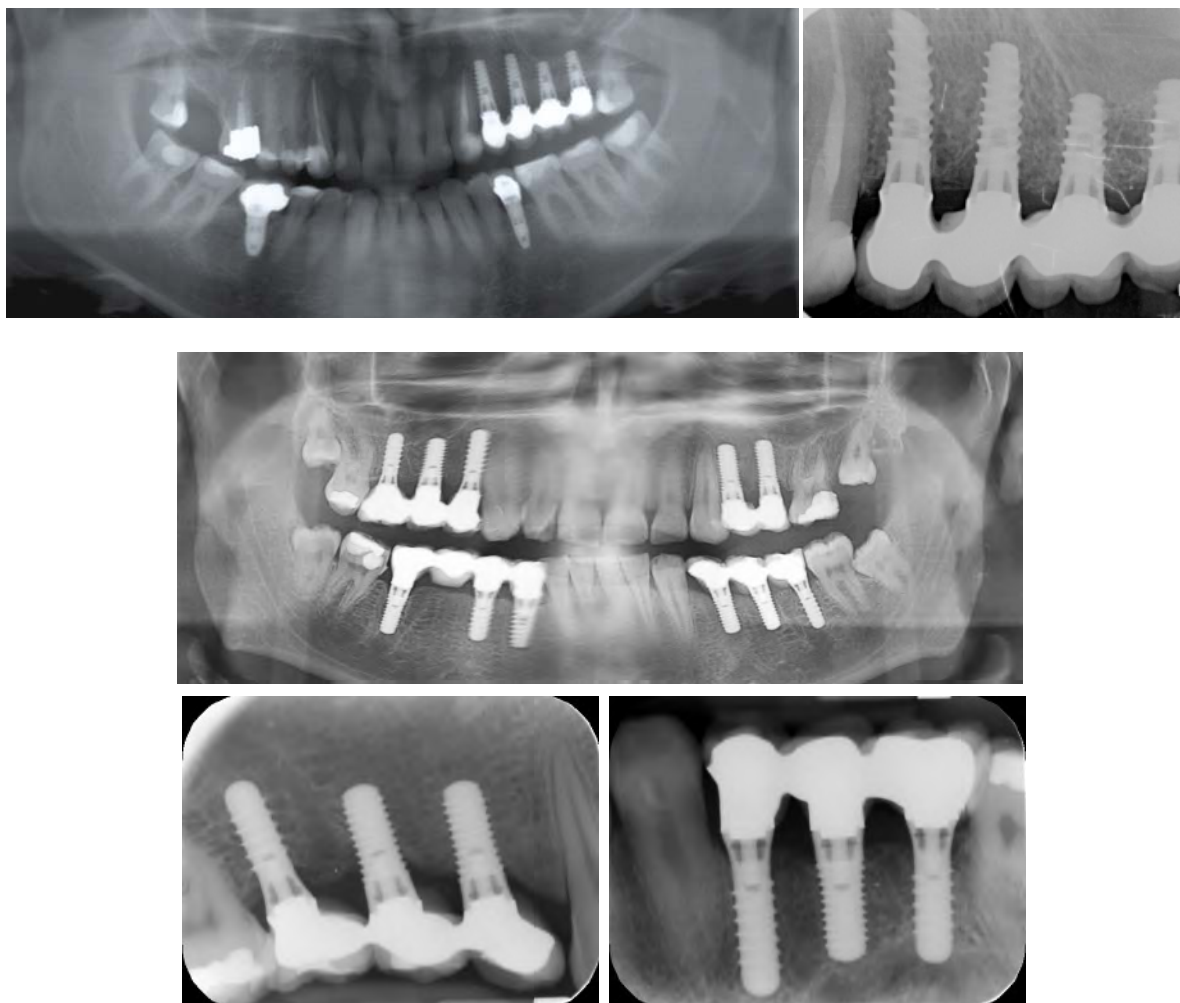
One-year postoperative radiographs
